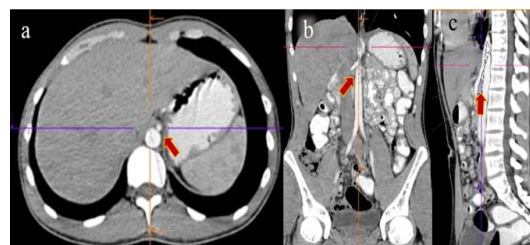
CT scan of abdomen (a-horizontal view, b-coronal view, c- sagittal view): reduced aortomesenteric angle and distance (arrows)
